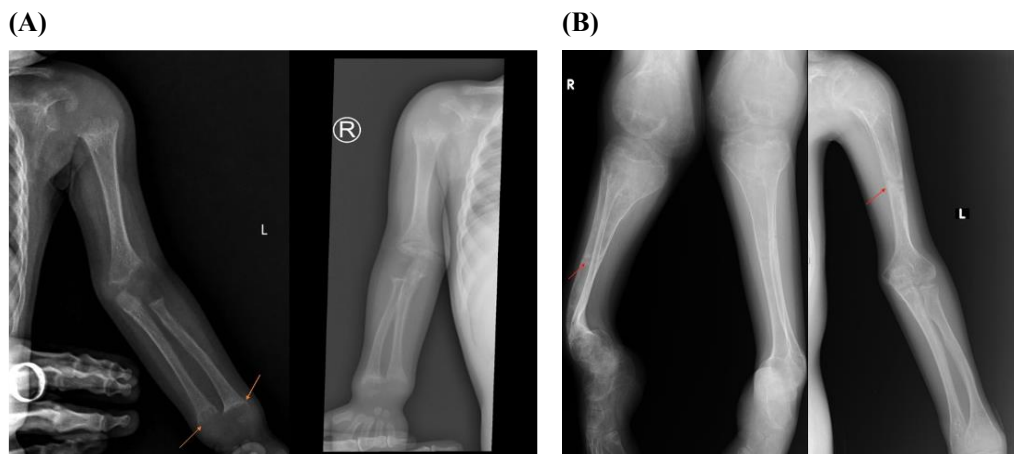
Radiographic images of two patients. (A) Patient 1: The arrow indicates concavity and irregularity at the metaphyseal ends of the long bones. (B) Patient 2: Marked bone deformities, decreased BMD, and the presence of pseudofractures (Looser's zones).
